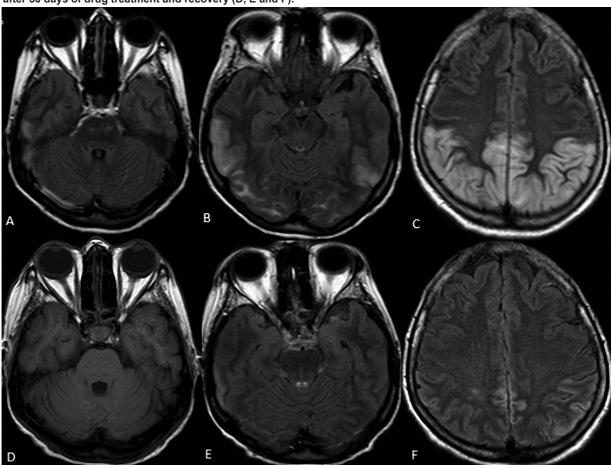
MR images revealing symmetrical hypersignals in FLAIR sequence during status epilepticus (A, B and C) and after 30 days of drug treatment and recovery (D, E and F).
